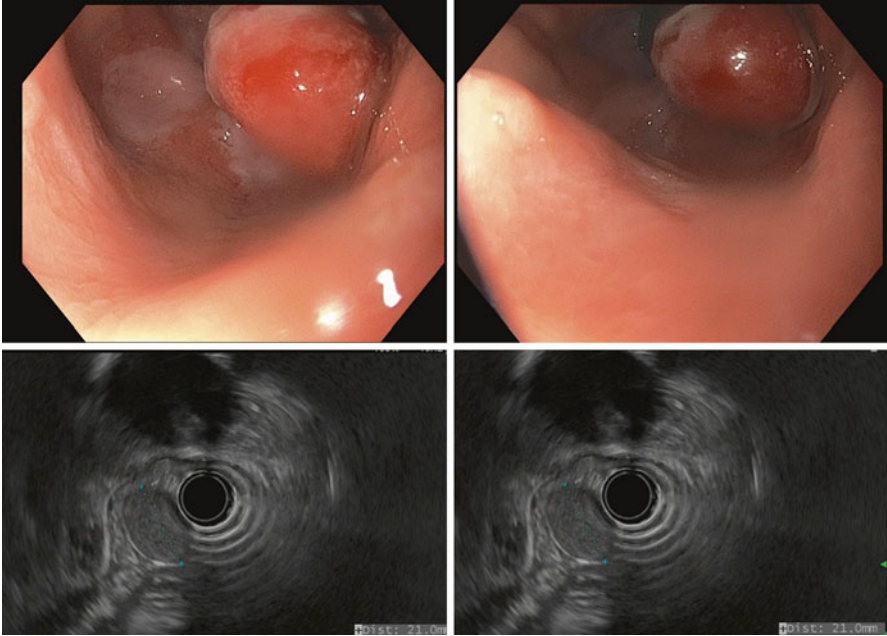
Endoscopy with endoscopic ultrasound. Esophageal polyp
